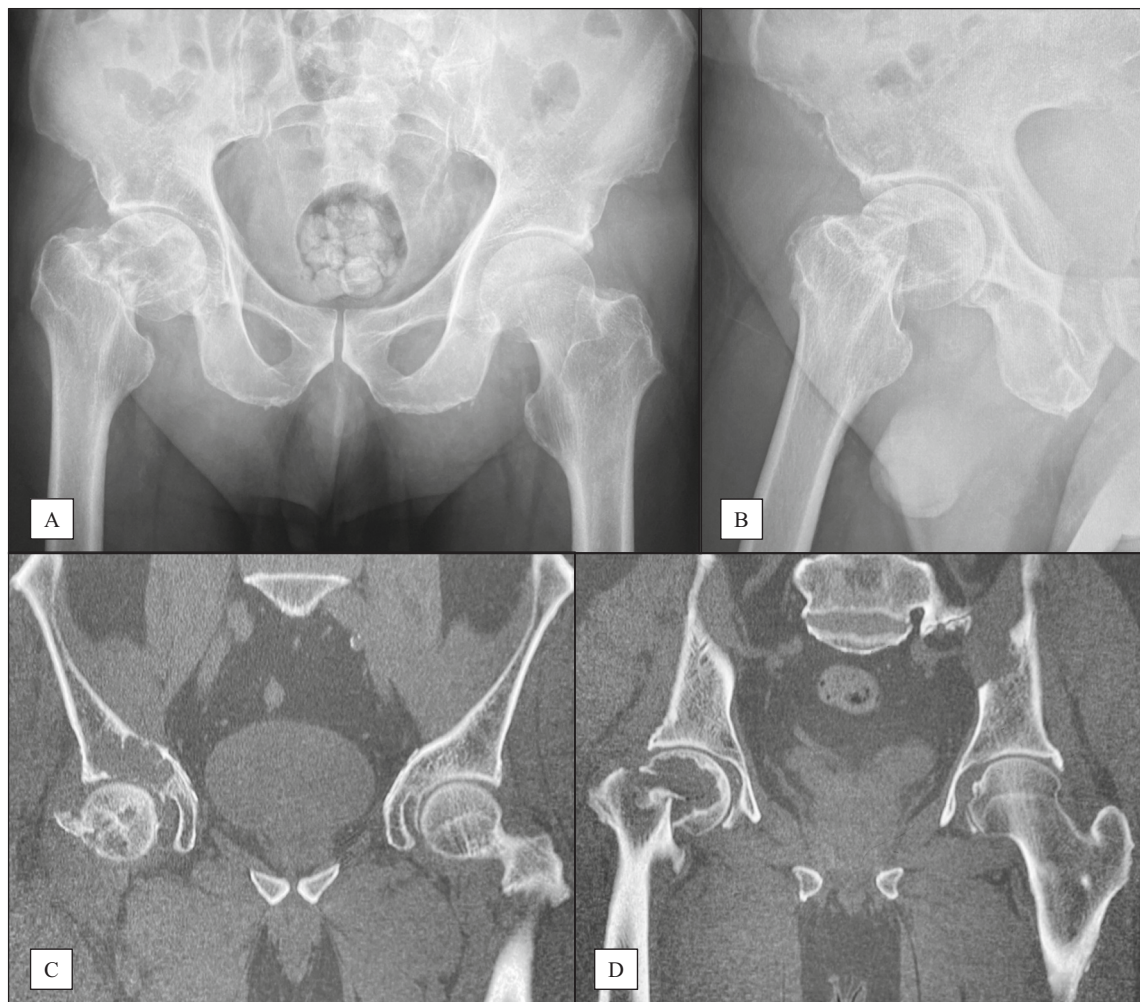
(A) Anteroposterior and (B) Lowenstein lateral preoperative radiographs of the hip joint demonstrated a metastatic lesion of the acetabular dome and a pathological displaced femoral neck fracture on the right side. (C) Coronal computed tomography demonstrated that the articular surface of the right acetabulum was disrupted combined with insufficient supportive subchondral bone because of the metastatic lesion. (D) Coronal computed tomography also showed the displaced pathological proximal femur fracture with a large metastatic lesion in the right femoral head and neck bone.
